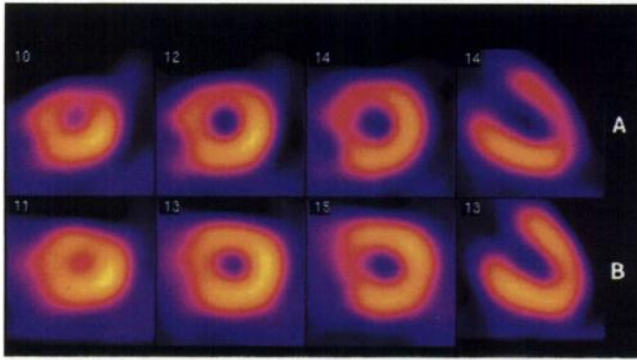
Stress SPECT ^{201}Tl images. (A) Standard reconstruction range from 45° RAO to 45° LPO. There is a perfusion defect of the anterior, anteroseptal, apical, and high lateral walls. (B) Reconstructed image set using projection data from an optimized range extending from 60° RAO to true posterior.
